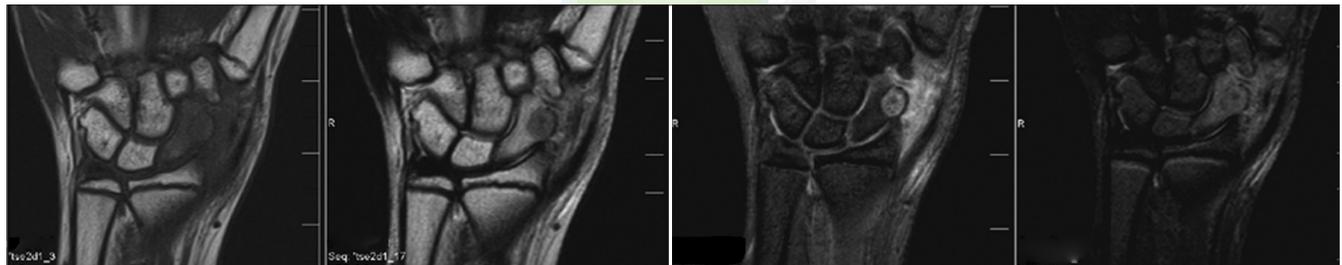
MRI scan of the wrist showing a well-defined T1- and T2-hypointense and gradient echo (GRE) and short-tau inversion recovery (STIR)-hyperintense lesion with a central hypointense nidus in all sequences involving the distal pole of scaphoid with bone marrow and soft tissue edema with synovitis of the wrist
